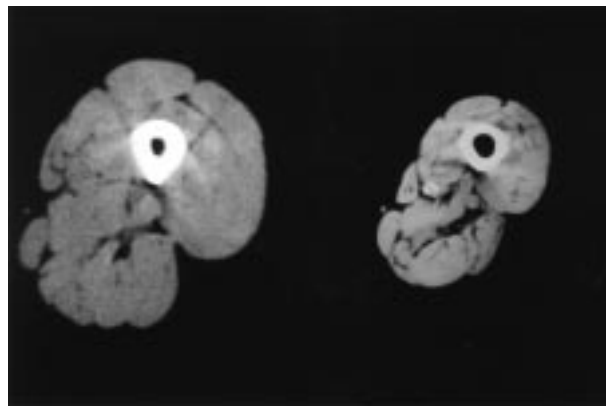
Cross-sectional images at mid-thigh (by computed tomography) from a healthy woman in her twenties and a healthy woman in her eighties, to the same magnification. Reproduced with permission from Young (1996).
